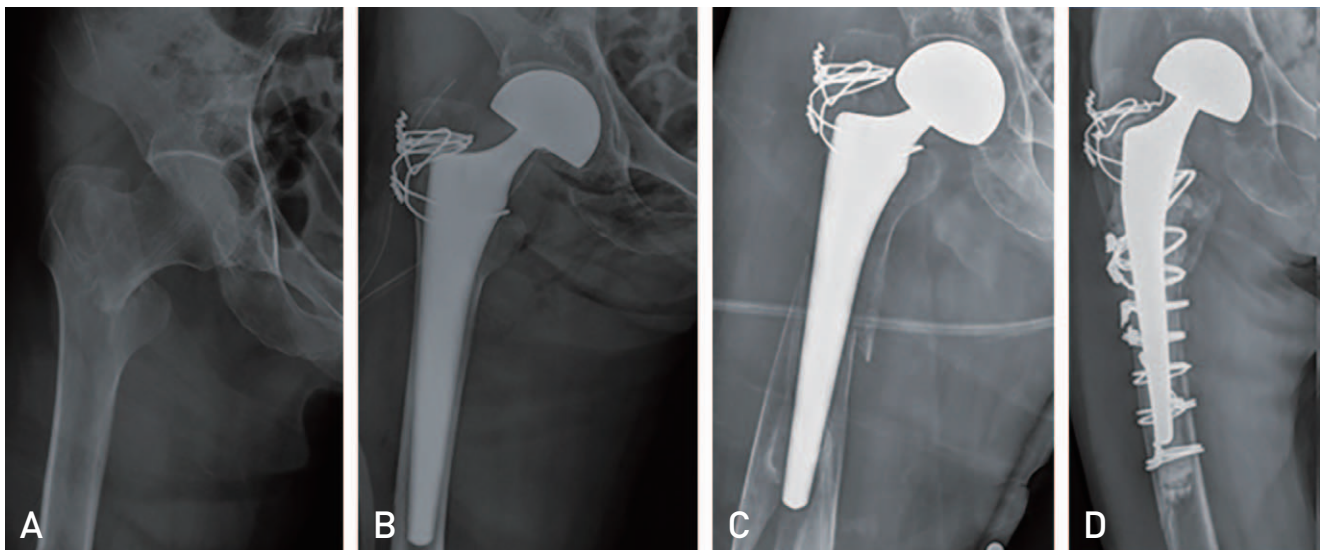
(A) Radiograph of a 74-year-old female with right intertrochanter fracture. (B) Postoperative anteroposterior (AP) hip radiograph. (C) Six years after periprosthetic fracture (Vancouver type B2) AP hip radiograph. (D) Cemented stem bipolar hemiarthroplasty.
